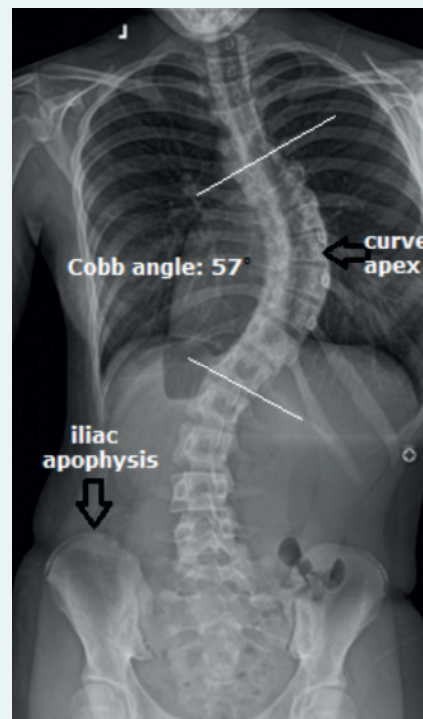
Posteroanterior radiograph of whole spine with Cobb angle 57°. On a posteroanterior view of the spine, tangents (white solid lines) are drawn along the superior endplate of the superior end vertebra and the inferior endplate of the inferior end vertebra. The Cobb angle is formed by the intersection of these two lines
